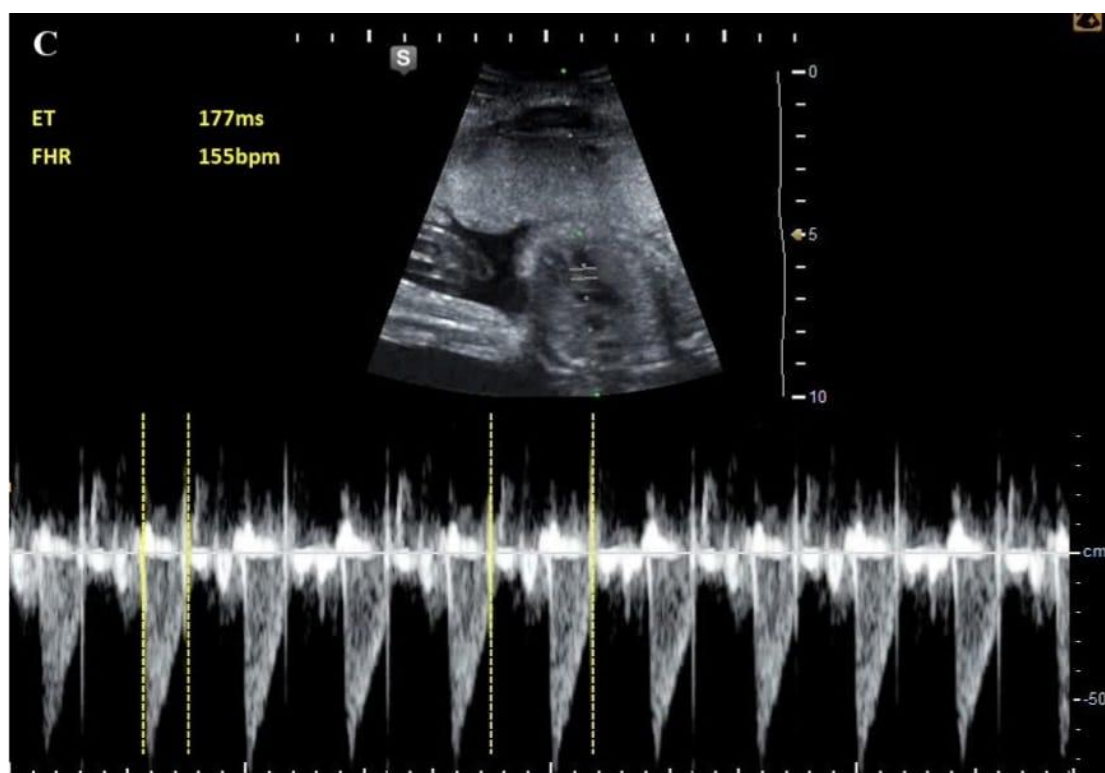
Measurement of right ventricular (MPI) using pulsed wave Doppler at the tip of tricuspid leaflets and measure (a) time interval from closure to aperture click of the tricuspid valve as shown in (B) and just below the PV (b) time interval between the aperture and the closure of the pulmonary valve was measured in (C) then MPI was calculated with following way (a-b)/b, with high Tei index of right MPI (290-177)/177=0.63 with fetal heart rate 152-155 bpm.
